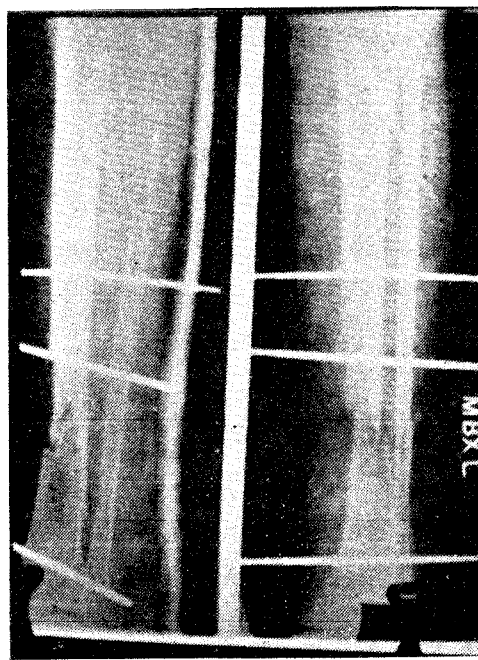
Pre-operative radiograph showing non-union and osteomyelitis at the fracture site.
